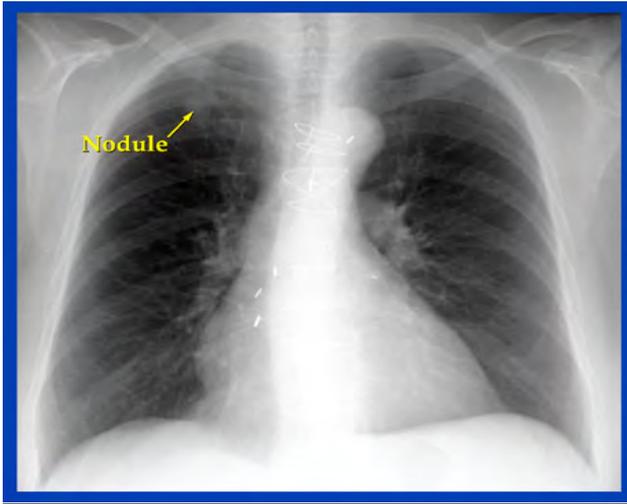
Chest x-ray and CT scan showing a nodule (less than three centimeters in diameter) without spread to adjacent structures.
